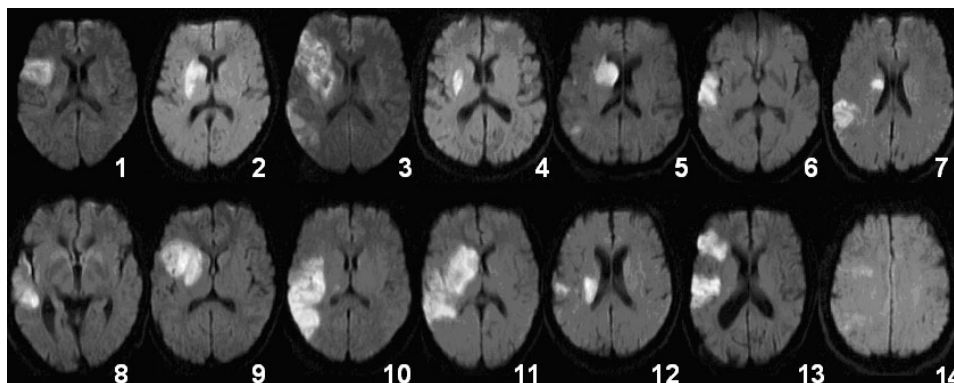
Site of infarction of 14 patients. Axial diffusion-weighted MRI scans at the level of maximum infarct volume for each aphasic patient. Left side of the figure corresponds to the left side of the brain.
